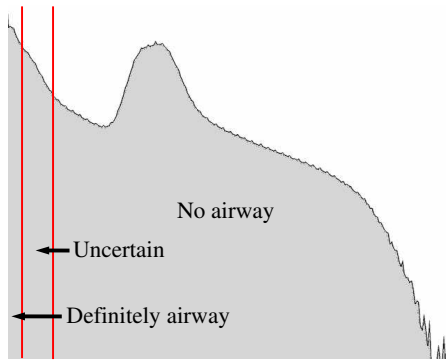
Logarithmic histogram of CT dataset.
